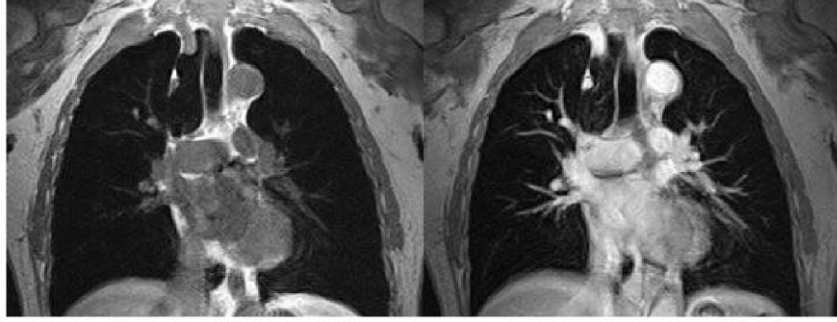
MRI scan image of the lungs^[18].
